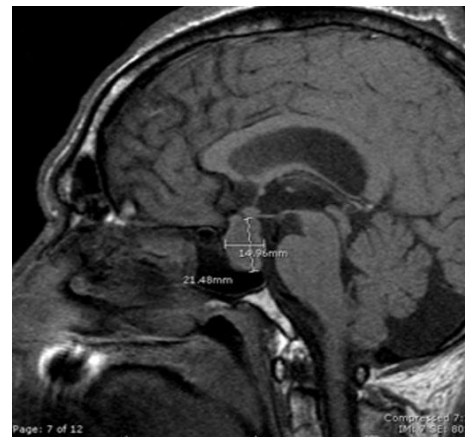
MRI showed a homogeneously enhancing hypointense T1/iso-intense T2 mass arising from the sella turcica.
